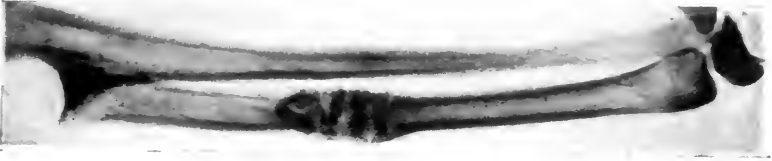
X-ray shows bone hypertrophy with union of fragments. Duration, 141 days.
